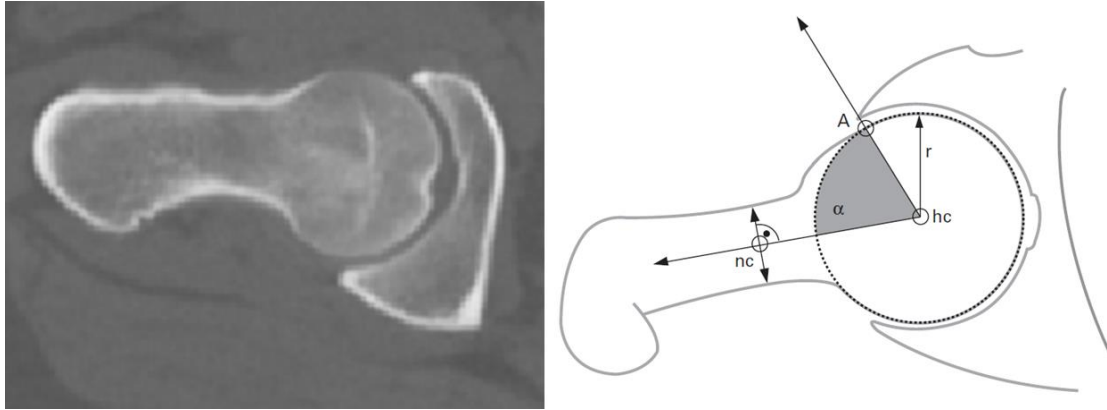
(Left) Reoriented pre-operative CT scan for assessing cam deformity. The plane is parallel to the femoral neck axis and passing through the center of the femoral head. (Right) α -angle measurement as defined by Nötzli et al. [106]. Briefly, a sphere is fit to the femoral head, and the sphere center is identified. A vector is drawn parallel to the femoral neck axis and passing through the center of the femoral head. Another vector is created from the center of the femoral head to the anterior location where the femoral head deviates from sphericity. The angle between these two vectors is the α -angle. A MATLAB algorithm permitted accurate identification of the vectors and α -angle.
